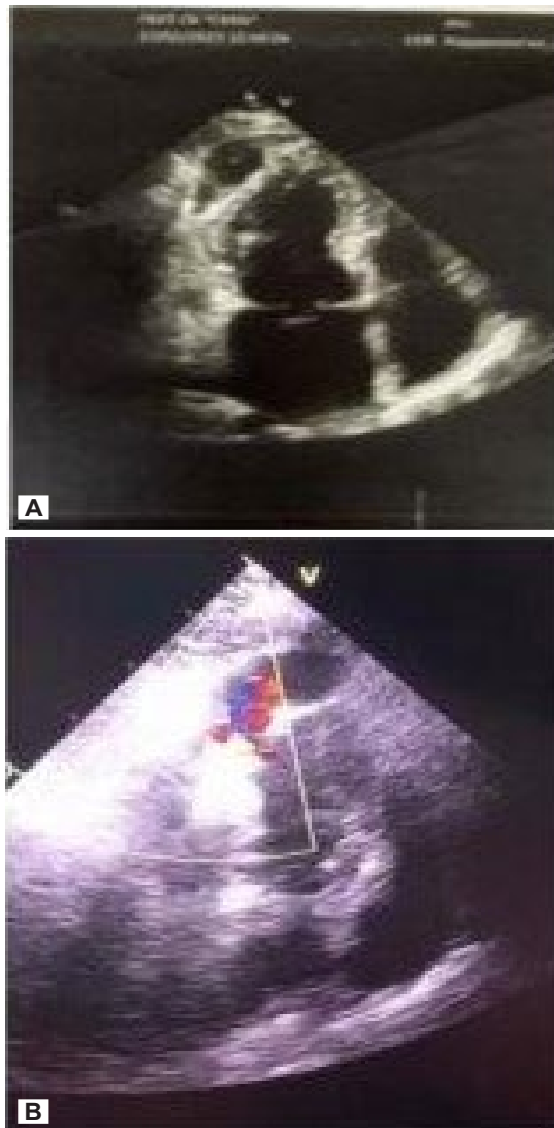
Echocardiogram: A – false aneurysm of the left ventricle; B – discharge of blood from the ventricle into the pseudoaneurysm cavity through the fistula
